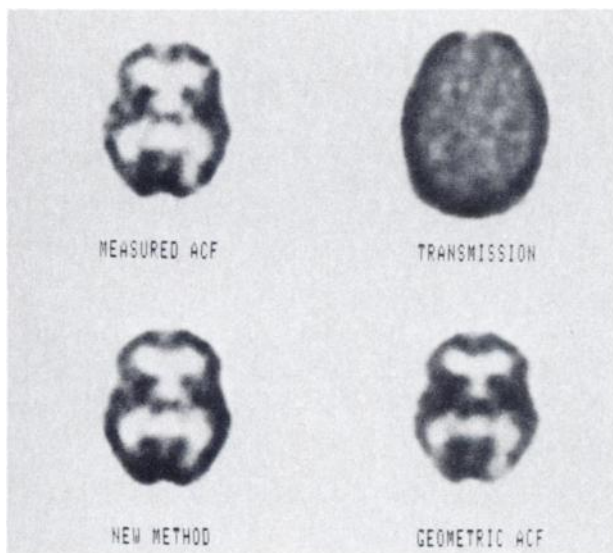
Images from another FDG study. Upper right shows transmission image (20 M counts) of brain at OM + 4 cm. Upper left is emission image (2.5 M counts) corrected with measured ACFs corresponding to upper right image. Lower left was by boundary method, lower right by geometric AC method. Qualitatively the three emission images are similar, although reconstructed radioactivities by geometric AC method are much lower than values from other two images (see Table 1).
